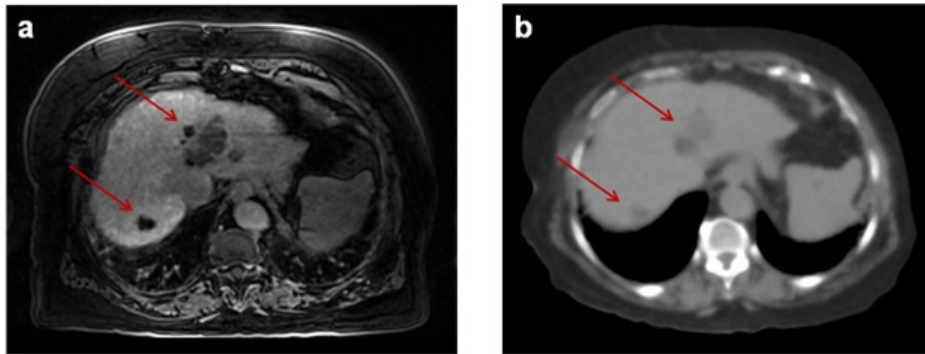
(a) MRI versus (b) CT of patient with primary liver cancer. The lesions, indicated by the red arrows, and their boundaries are much clearer on the MRI compared to the CT.
